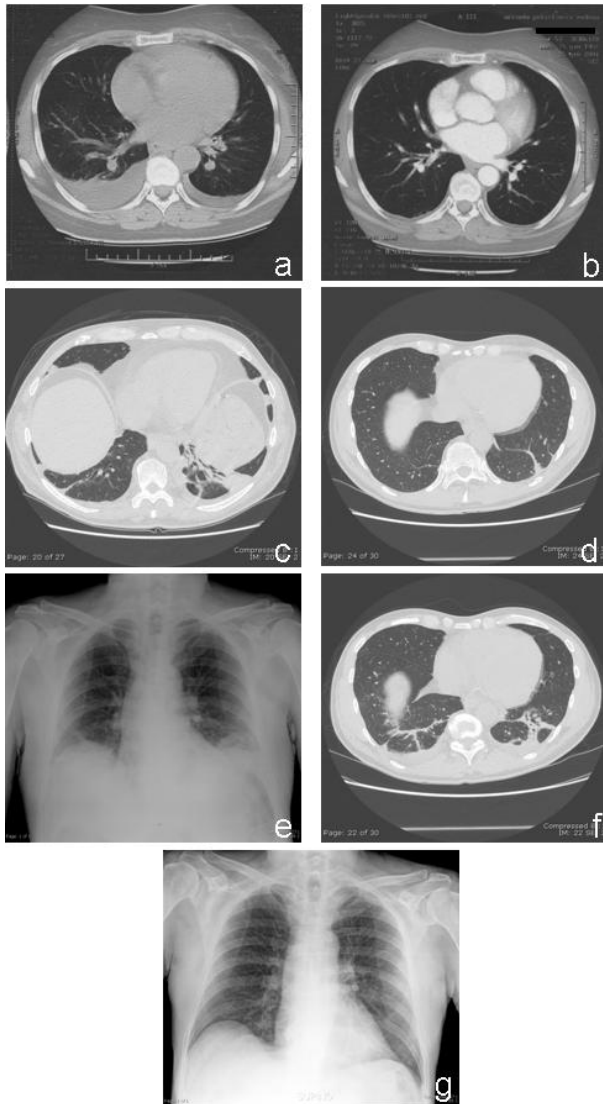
Radiological examinations in the three leukemic patients receiving high dose cytarabine. Early lung infiltrates in leukemic patients characterised by chest X-ray and/or HRCT (a,c,e,f); complete and spontaneous resolution in 48-72 hours (b,d,g).
